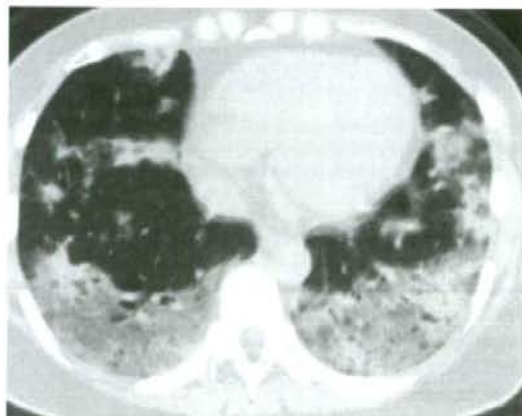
Chest CT scan before initiating methylprednisolone demonstrating diffuse interstitial lesions
